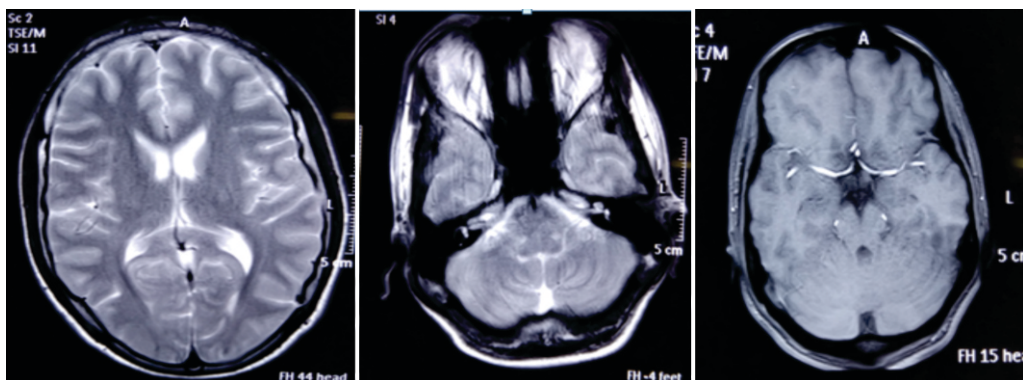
showing resolution of lesions on MRI Brain done 2 months after Thymectomy.
